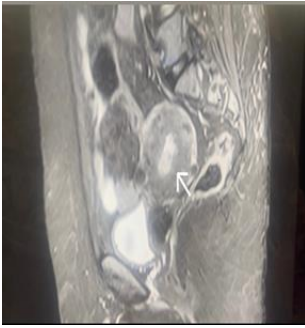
MRI suggested irregular and thickened endometrial lining with invasion of ~50% of the myometrium in left postero-lateral aspect. Possibility of endometrial carcinoma appears.
